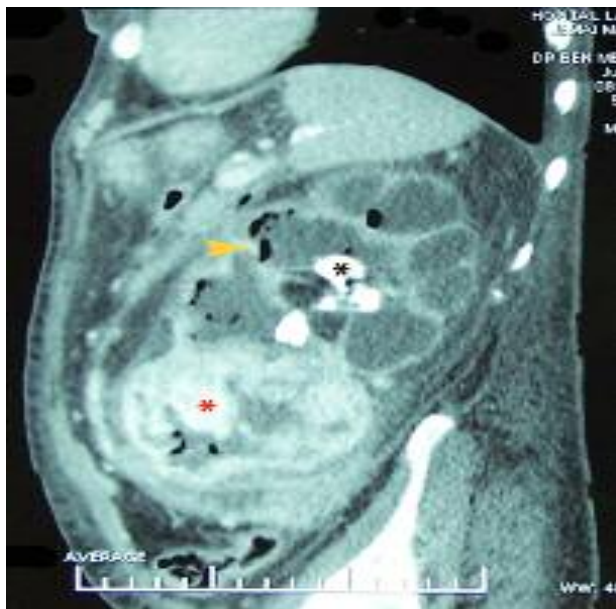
CT scan: Left hydronephrosis with gas (arrow) in the collecting system, renal parenchyma and the perinephric space; staghorn urinary stone (black asterix) and lower pole tumor (red asterix).
